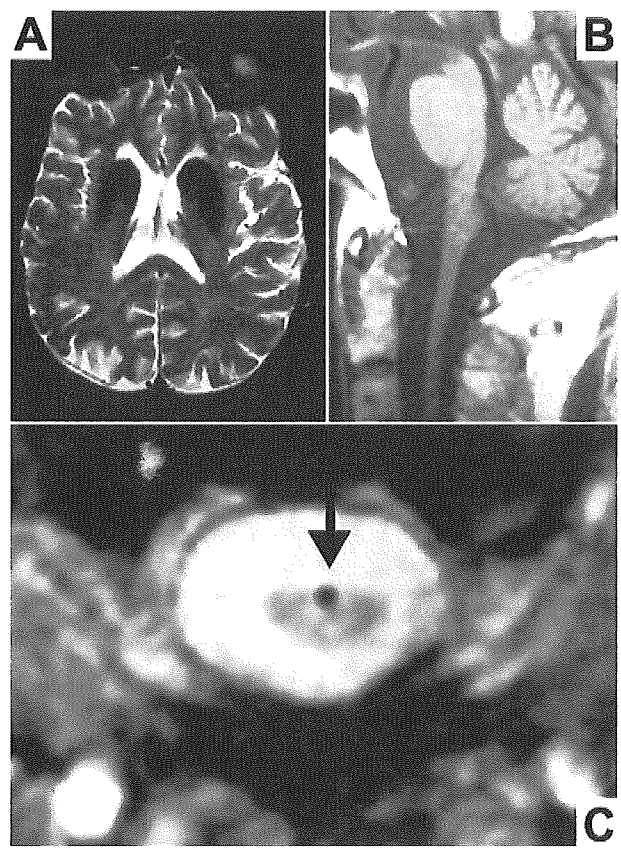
Axial T2-weighted (TR, 2,400; TE, 100) (A) spin-echo image shows symmetric hypointensity of the caudate and putamen and along the lateral ventricular walls without signal abnormality of the periventricular white matter. Sagittal T1-weighted (TR, 500; TE, 14) (B) spin-echo image shows marked thinning of the medulla and of the upper cervical spinal cord. Axial T2*-weighted gradient-echo image (TR, 500; flip angle, 20 degrees; TE, 25) of the spine at C2 (C) demonstrates dot-like hypointensity (arrow) in the anterior sulcus of a thinned spinal cord.
